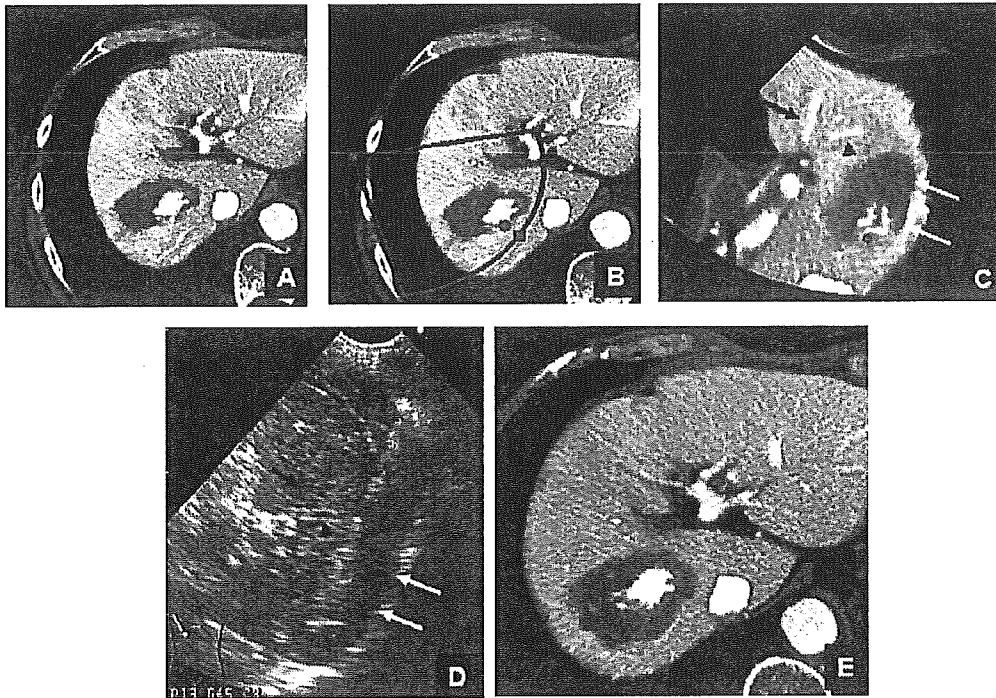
Treatment of hepatocellular carcinoma using virtual imaging. (A) Dynamic CT showing incomplete necrosis. (B) A gray point is placed on the target site. (C) The virtual image including the gray point is revealed. Anterior branches of portal vein (black arrow and arrowhead) and the necrotic area from previous RFA (white arrow) are shown. (D) Comparison of the image from (C) on conventional US. (E) After treatment, dynamic CT reveals a complete necrotic area.
